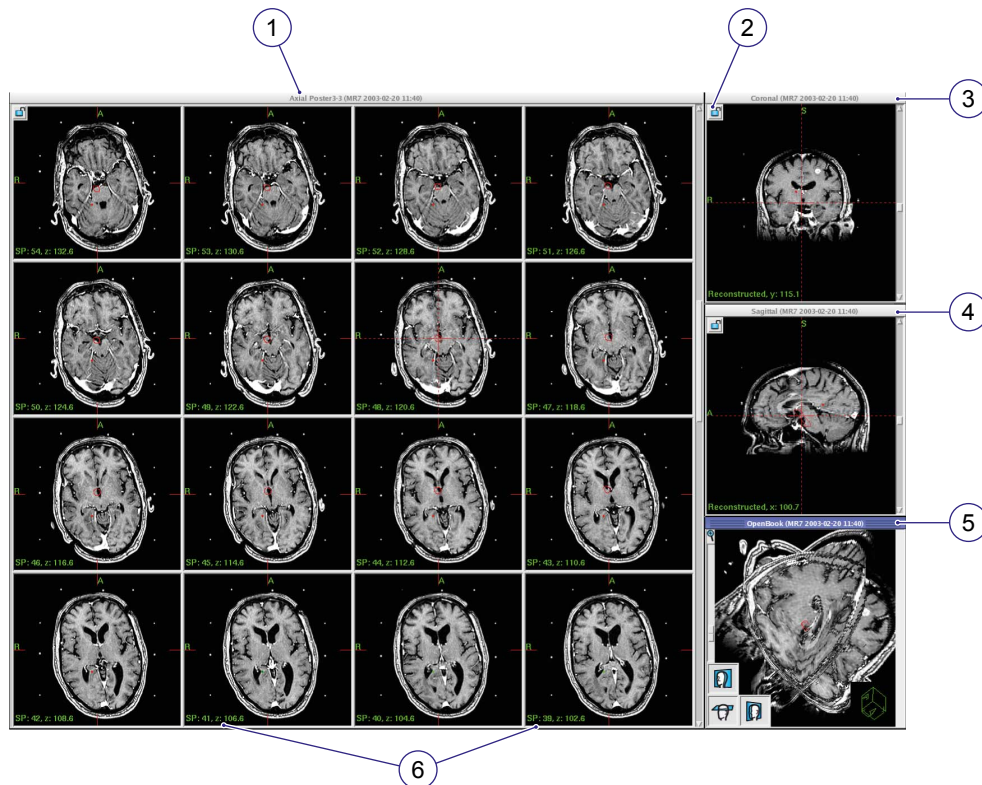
Typical workspace with MR images
